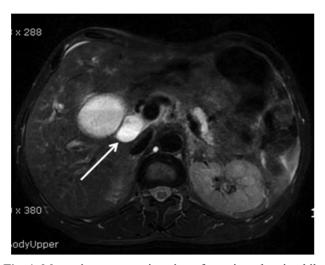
Magnetic resonance imaging of a patient showing bile duct dilation.
